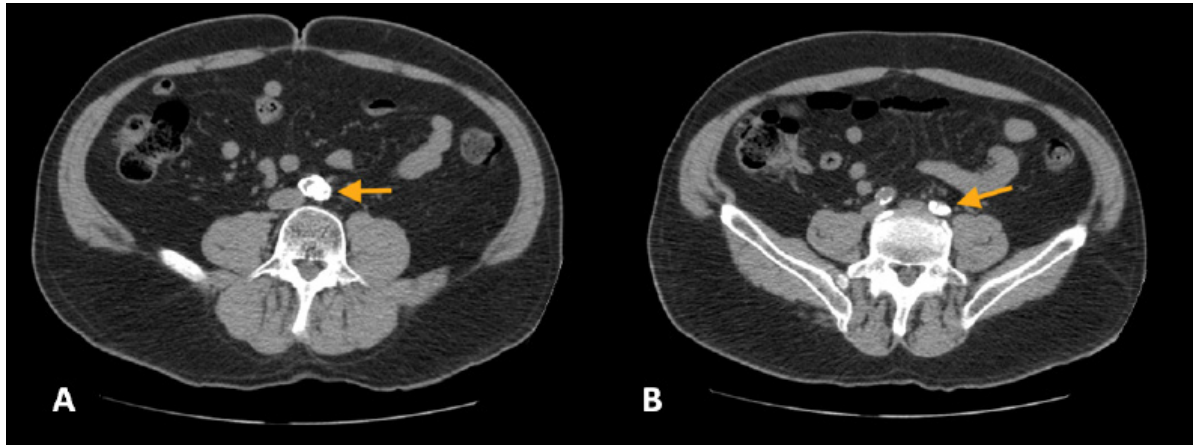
Coronary computed tomography angiography without contrast in axial projections. A) Eccentric sub-occlusive lesion at left common iliac artery proximal level with coronary calcium compromising almost the entire lumen. B) Eccentric severe lesion at left common iliac artery distal level.
